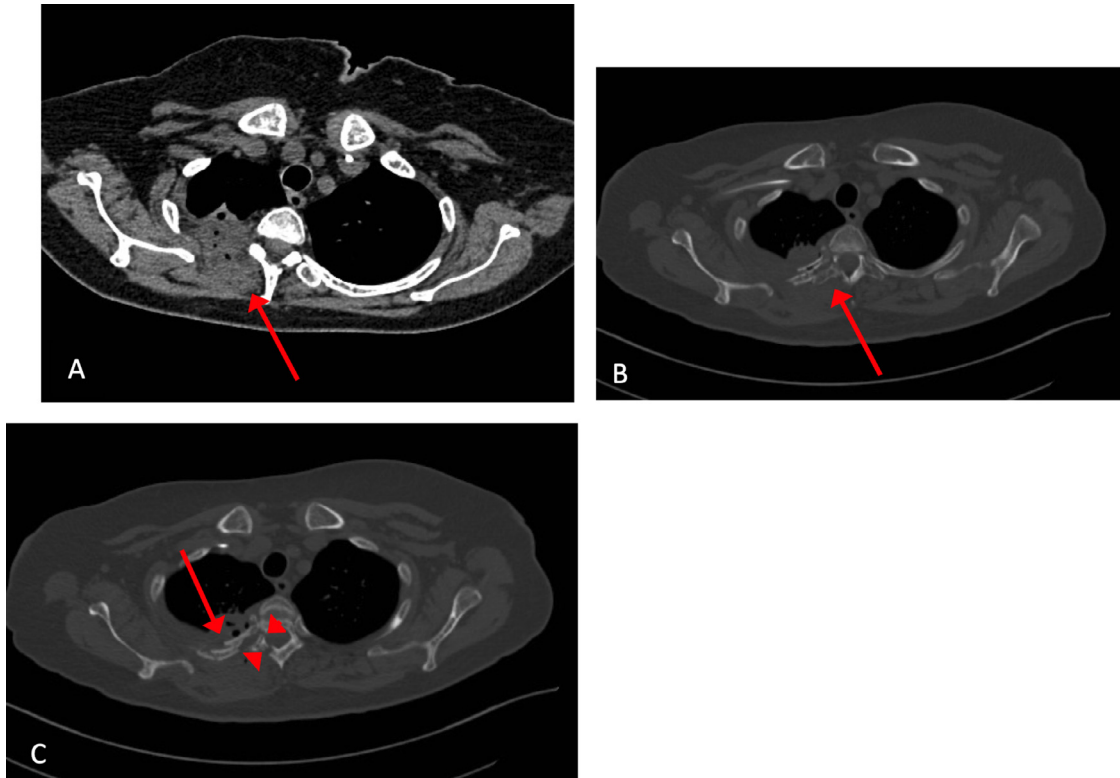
Non-enhanced HRCT of the chest: (A) Right apical cavitory lesion with involvement of the right paraspinal muscles (arrow). Multiple air foci are present within the collection and in the paraspinal muscles involvement. (B) Adjacent osseous rarefaction is noted at the posterior aspect of the right 3rd and 4th ribs as well as right transverse processes of the same levels. (C) Displaced fractures of the right 3rd and 4th ribs are present (arrow), with involvement of the T3 right transverse process, lamina, and pedicle (arrowheads).
